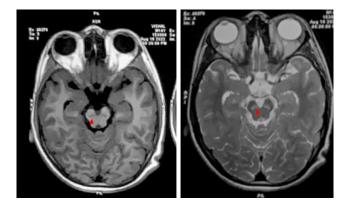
AxialT1 and T2 weighted magnetic resonance imaging of brain show substantia nigra hypointensity and hyperintensity respectively suggesting degeneration and gliosis.(red arrows)
